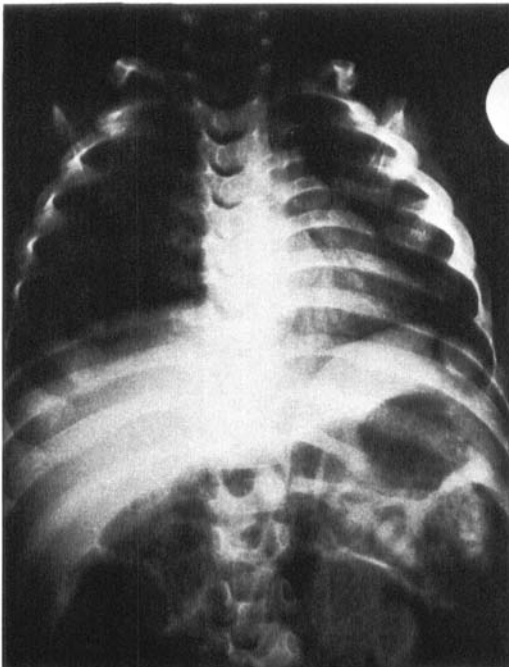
Classical ossification in the costochondral junction on the chest X-ray.
